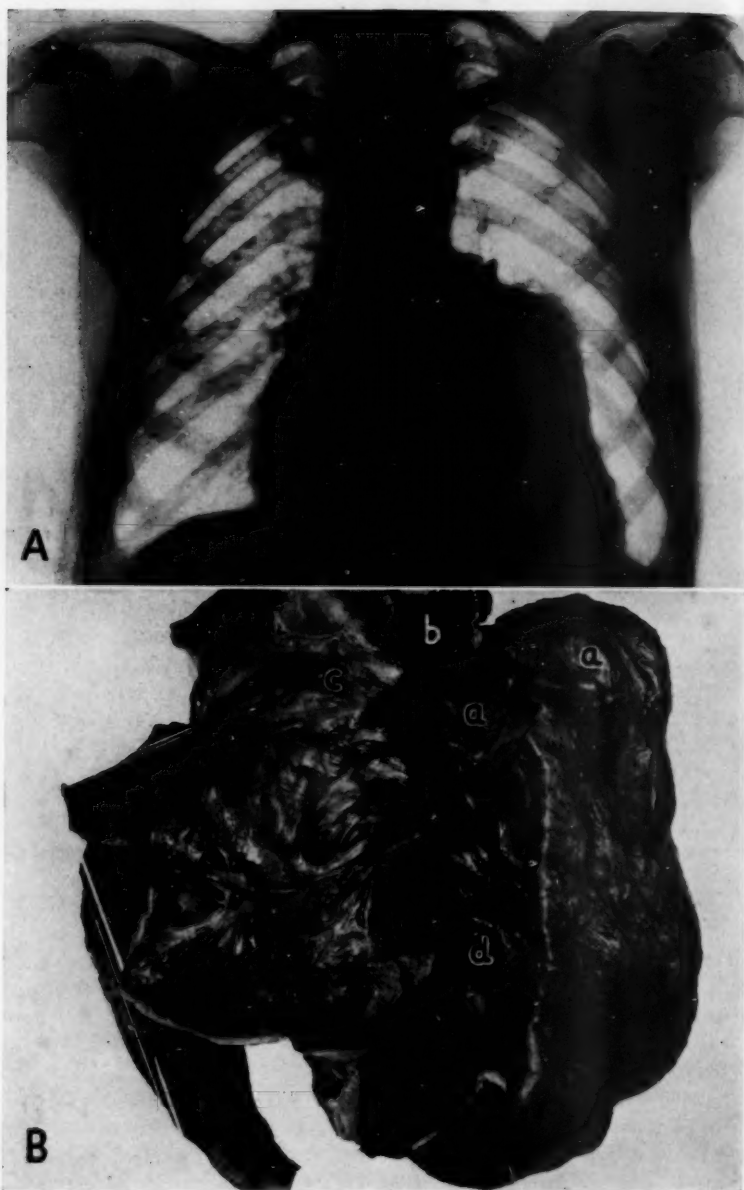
(case 1).—*A*, roentgenogram of the chest, showing marked enlargement of the heart to the right and left. The large prominence in the region of the pulmonary conus was shown to be due to a gummatous aneurysm at the base of the left ventricle. *B*, anterior view of the heart. Note the large saccular eminence (*a*) subjacent to the pulmonary conus (*b*) and protruding well into the pulmonary subvalvular region (*c*), creating the effect of a pseudostenosis. Near the apex on the septal wall is a firm yellowish myocardial gumma (*d*).
